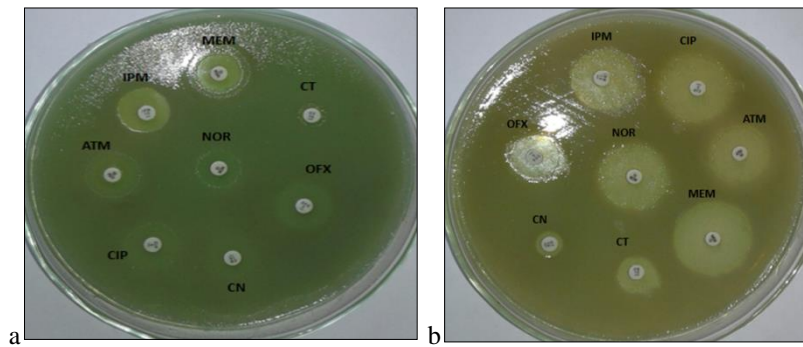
a) Antibiotic sensitivity test by disc diffusion method for *Pseudomonas aeruginosa* strain 10 showing resistance to the following antibiotics: Meropenem (MEM), Imipenem (IPM), Colistin (CT), Aztreonam (ATM), Gentamicin (CN), Ofloxacin (OFX), Norfloxacin (NOR) and Ciprofloxacin (CIP) before exposure to the SIC of aqueous garlic extract; b) Antibiotic sensitivity test by disc diffusion method for the same strain after exposure to the SIC of aqueous garlic extract showing increased inhibition zone to the same antibiotic discs tested.
